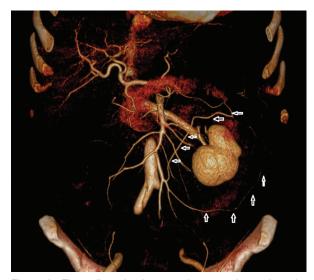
Three dimensional-computed tomography angiography: Riolan's arc (transverse arrows) and Drummond's marginal artery (longitudinal arrows).
